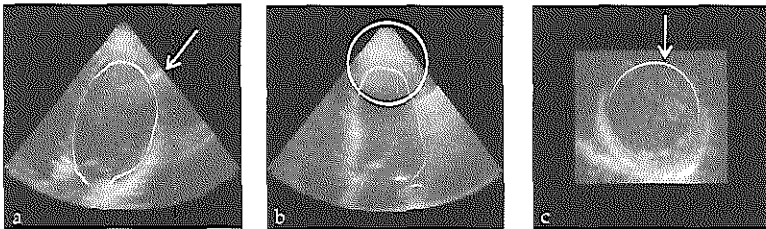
Typical artifacts in ultrasound images. (a) Side-lobe artifact in four-chamber image; (b) near-field artifact in four-chamber image; (c) shadowing or drop-out in short-axis image.
